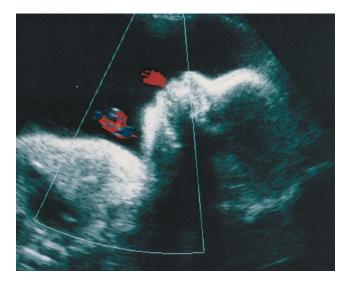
Color flow Doppler study demonstrating fetal vomiting in a case of duodenal atresia.
